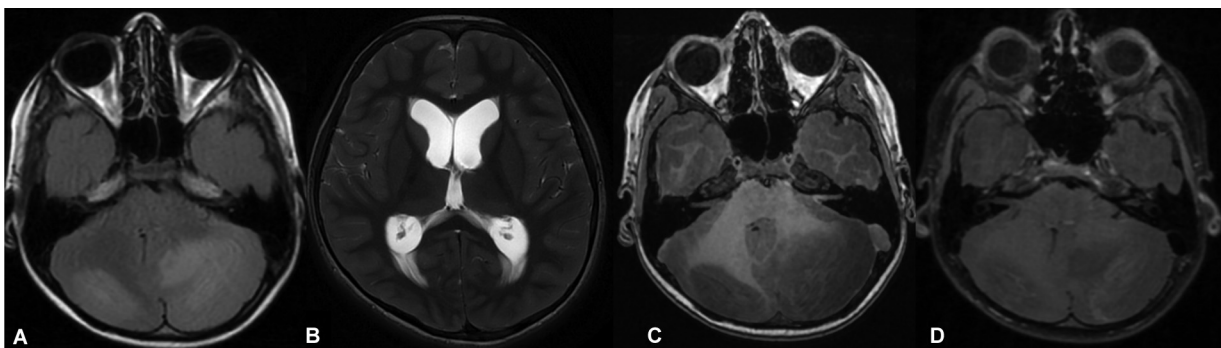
A 12-year-old boy presented with fever 7 days with headache and altered sensorium, diagnosed coronavirus disease 2019 (COVID-19) on presentation. The axial MRI (A, B, and C) images show asymmetrical FLAIR hyperintensity in bilateral cerebellum (left > right) with effacement of 4th ventricle leading to hydrocephalus. The postcontrast scan (D) shows ill-defined enhancement of cerebellar folia. The features are consistent with COVID-19 associated acute cerebellitis.
